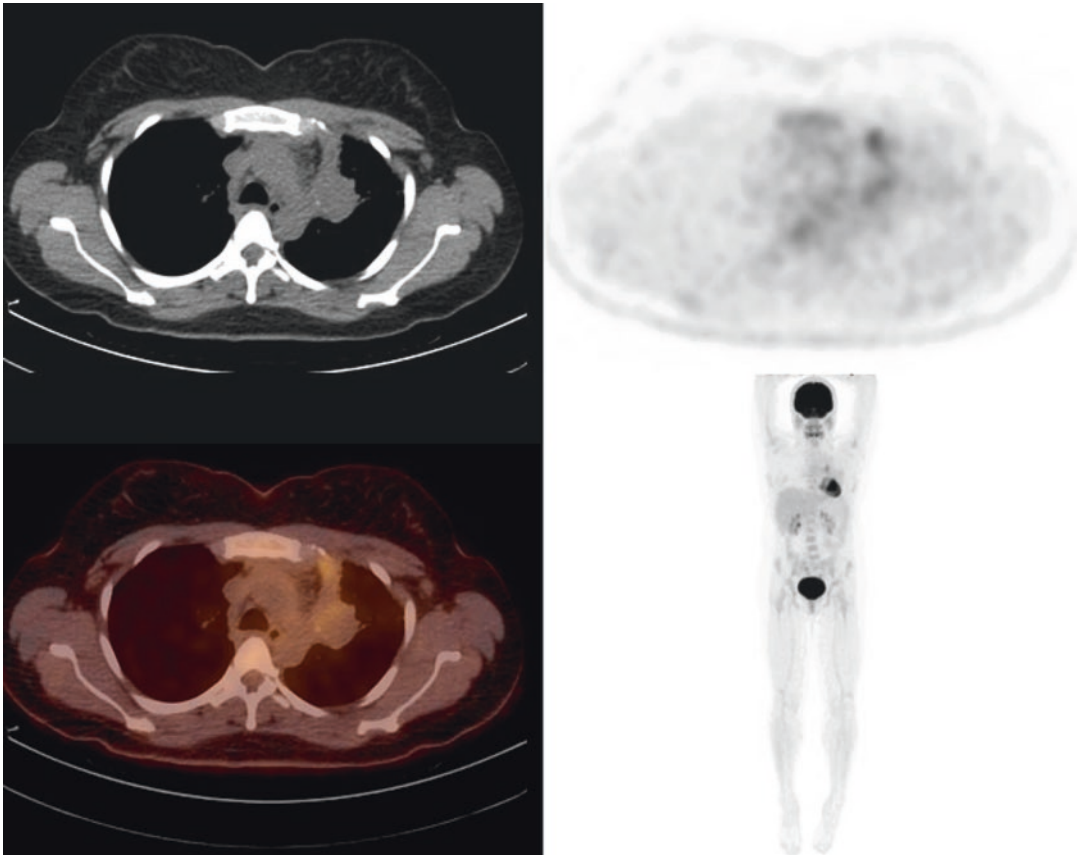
A 37-year-old female presenting with a left lung mass. PET/CT images demonstrate a left upper lobe mass with SUV max 2.0. Subsequent biopsy of the mass revealed a well-differentiated carcinoid tumor
